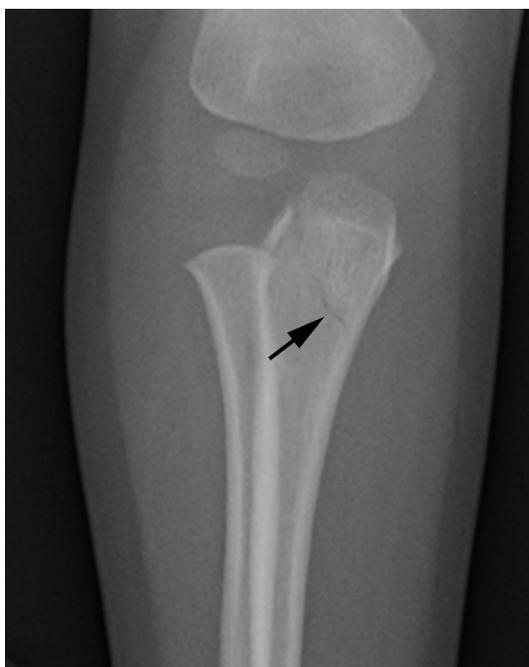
AP radiograph of the elbow in a 32-month-old with a nondisplaced olecranon fracture (*arrow*).
